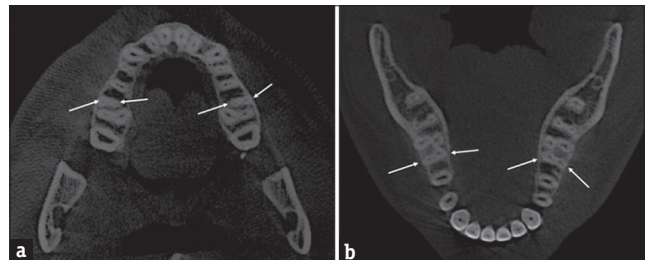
Three-dimensional cone-beam computed tomography showing (a) extra canal in the upper molars and (b) extra canal in the lower molars
